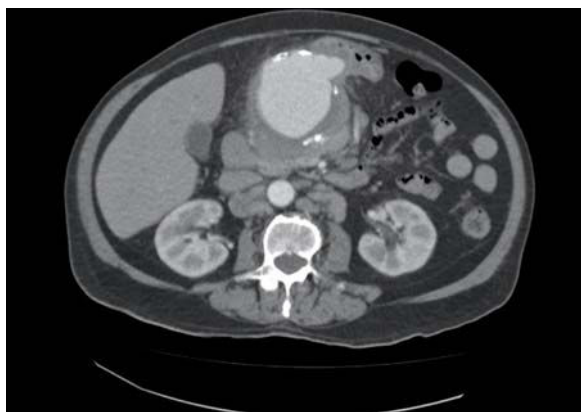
CT angiography showing hepatic artery aneurysm.
